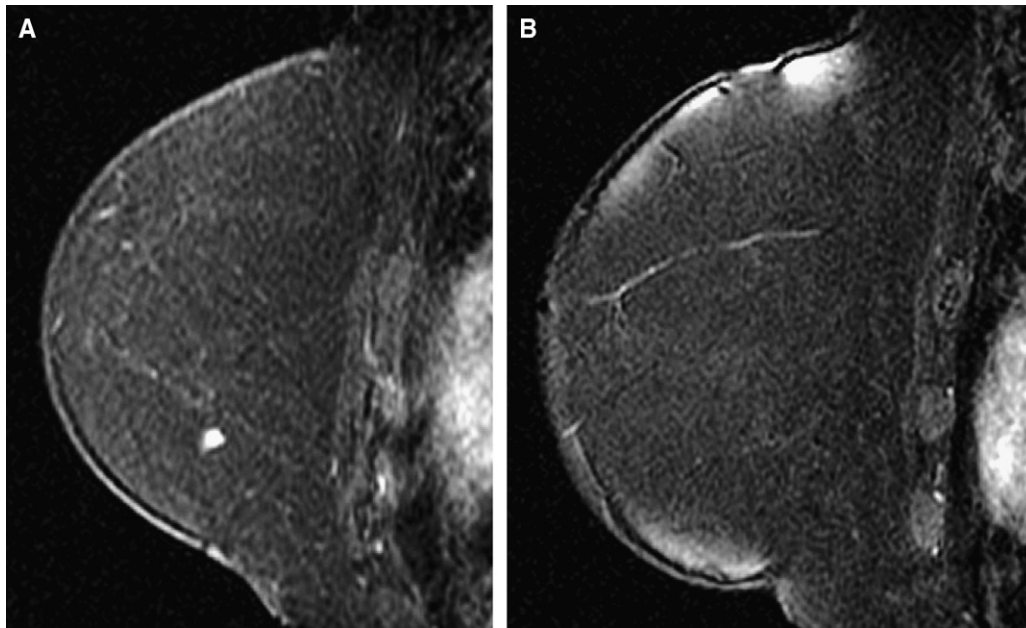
Small enhancing mass in the medial breast (A) was not visible on the day of biopsy (B). The biopsy was canceled and the patient scheduled for follow-up MRI in 6 months' time.
